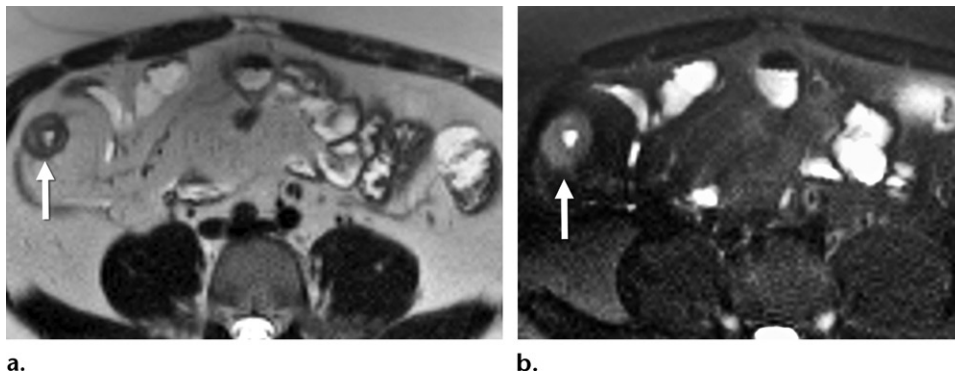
Intramural edema. Axial T2-weighted MR enterographic images with biphasic oral contrast material without (a) and with (b) fat suppression in a patient with Crohn disease show bowel wall thickening in the distal ileum, with increased mural signal intensity (arrow in a). On the fat-suppressed T2-weighted image, there is persistent increased signal intensity in the thickened bowel wall (arrow in b). This finding confirms that edema accounts for the high signal intensity rather than fat, which would have lost signal intensity with this sequence.
